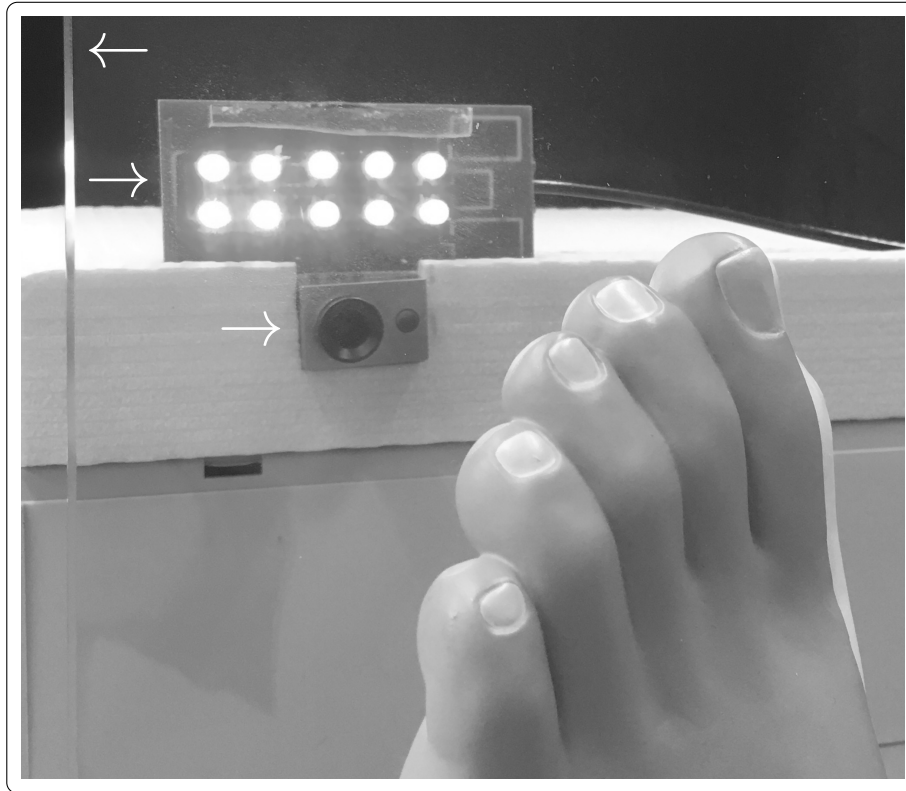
Setup for PPGi acquisition during 7 T MRA. Arrows indicate from top to bottom: glass plate, dedicated LED illumination, UHF MRI-compatible camera.
